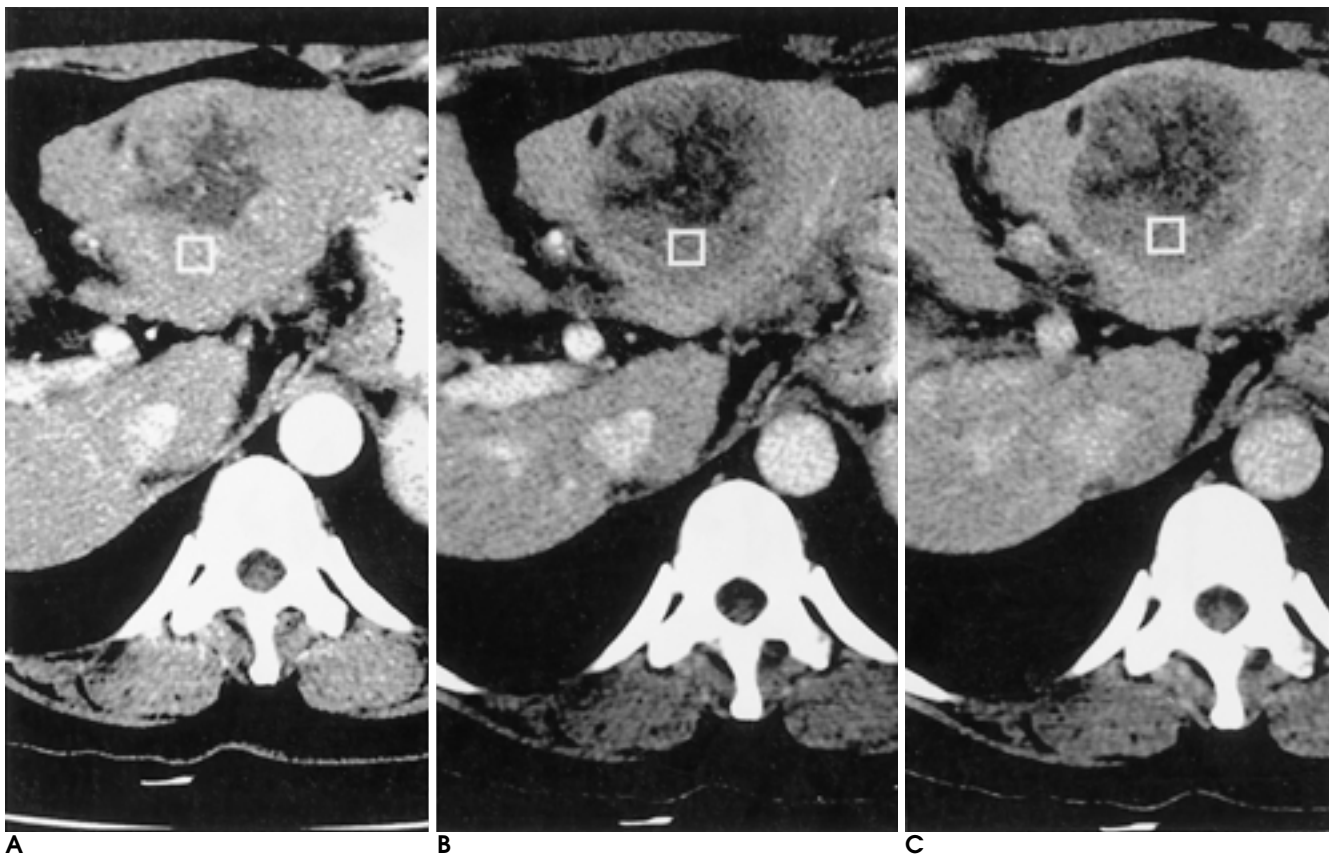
Triphasic liver CT scan of HCC with heterogeneous attenuation. A. arterial, B. portal, and C. delayed phase sections. Rectangular cursors are placed at enhancing solid portion of HCC.
